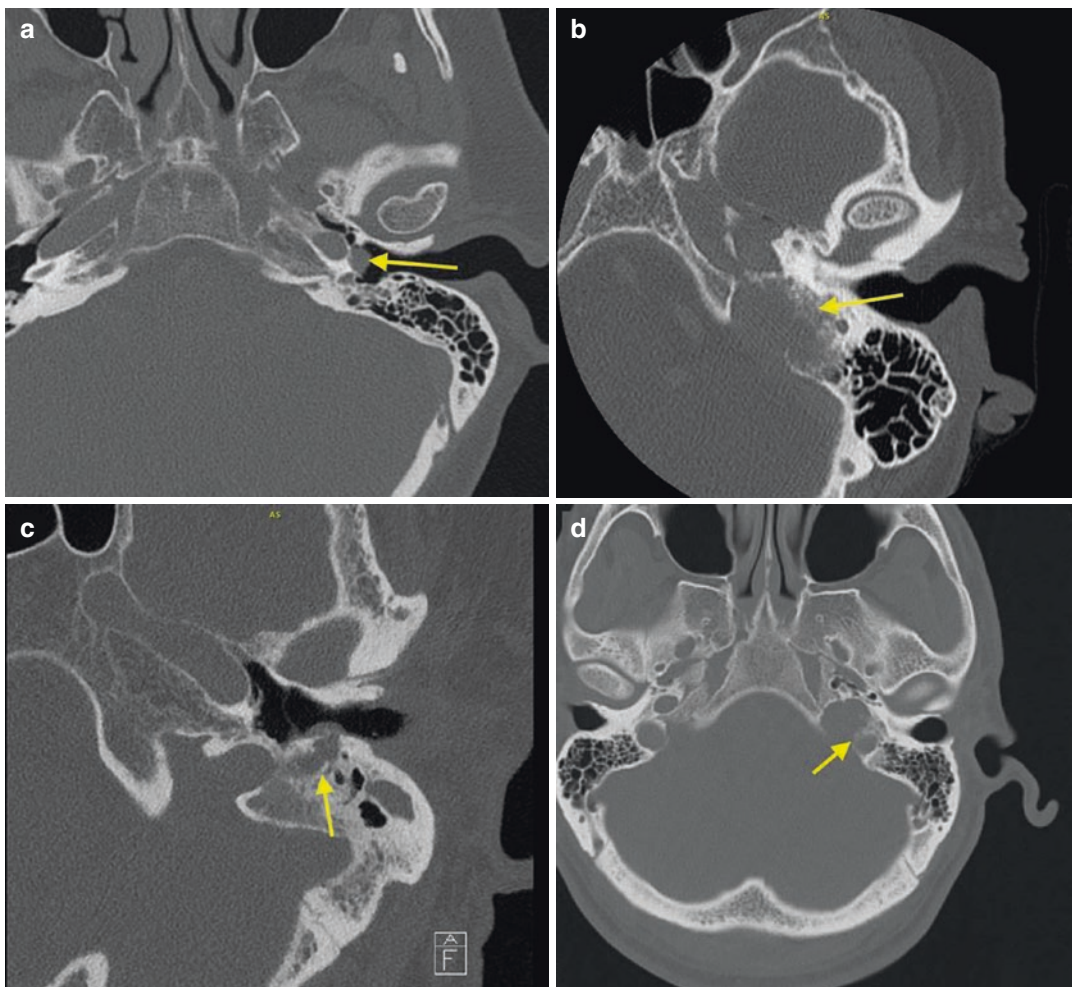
(a) Axial CT demonstrating an isolated retro-tympanic mass located in the hypotympanum and over the promontory surface indicative of a tympanic paraganglioma. (b) Axial temporal bone CT demonstrating an extensive left-sided jugular paraganglioma with erosion of the jugulotympanic spine and infralabyrinthine-retrofacial air cell system. (c) Axial CT demonstrating a rare case of a
